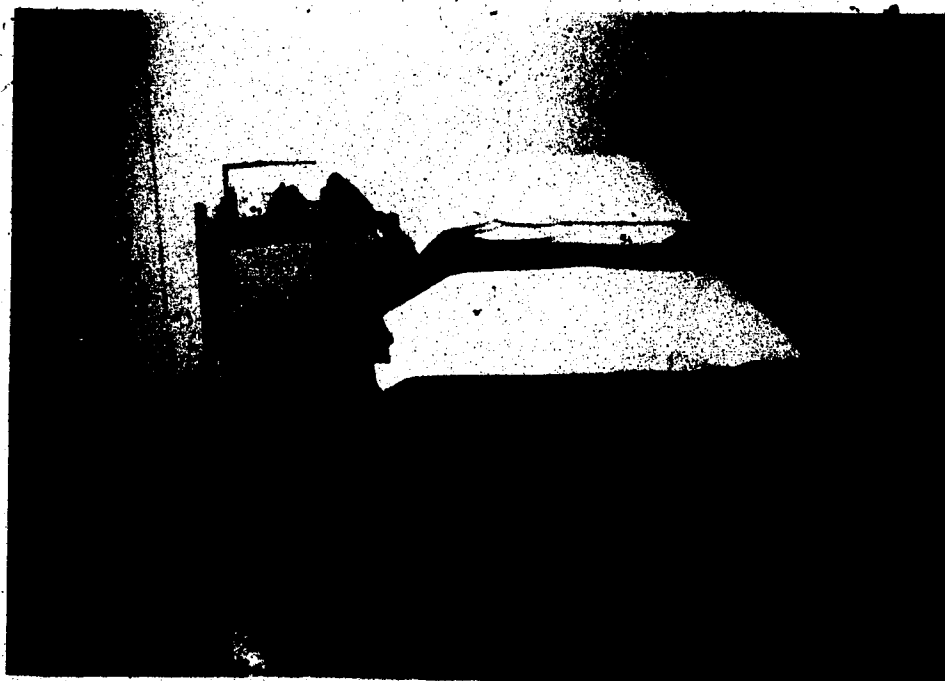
ULTRASOUND APPARATUS AND TREATMENT COUCH
